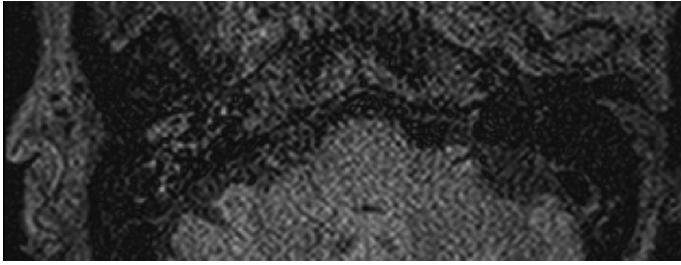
Picture of the inner ear before gadolinium enhancement in case 4 3D-FLAIR sequence.
